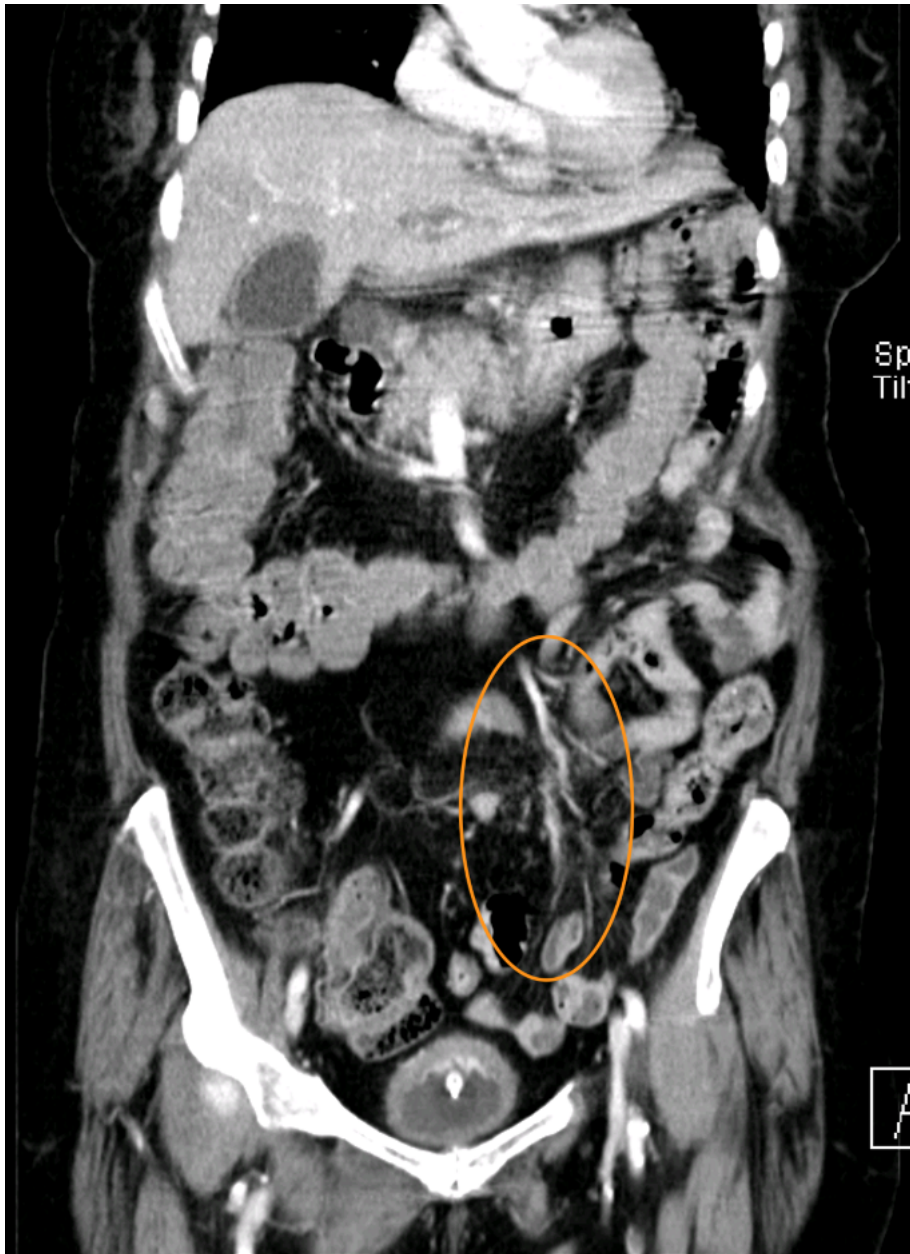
Abdominal CT in arterial phase. The orange circle indicates congestion of the tributary mesenteric vessels. Preserved intestinal wall uptake.
